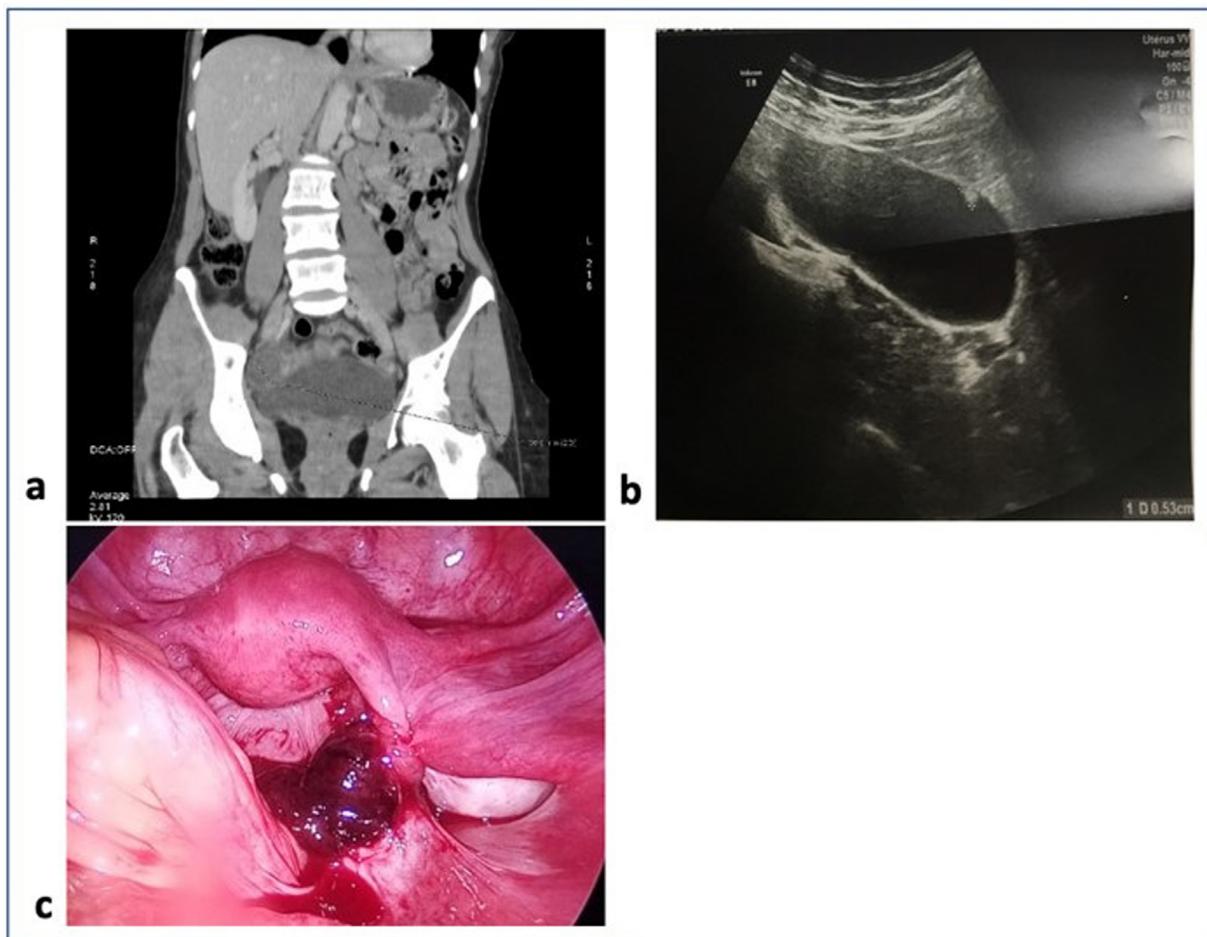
a. Abdominopelvic CT-scan view, visualization of elongated structure interpreted as hydrosalpinx. b. Suprapubic US view showing a normal-appearing ovary with a suspected paraovarian cyst. c. laparoscopic appearance of twisted fallopian tube.
